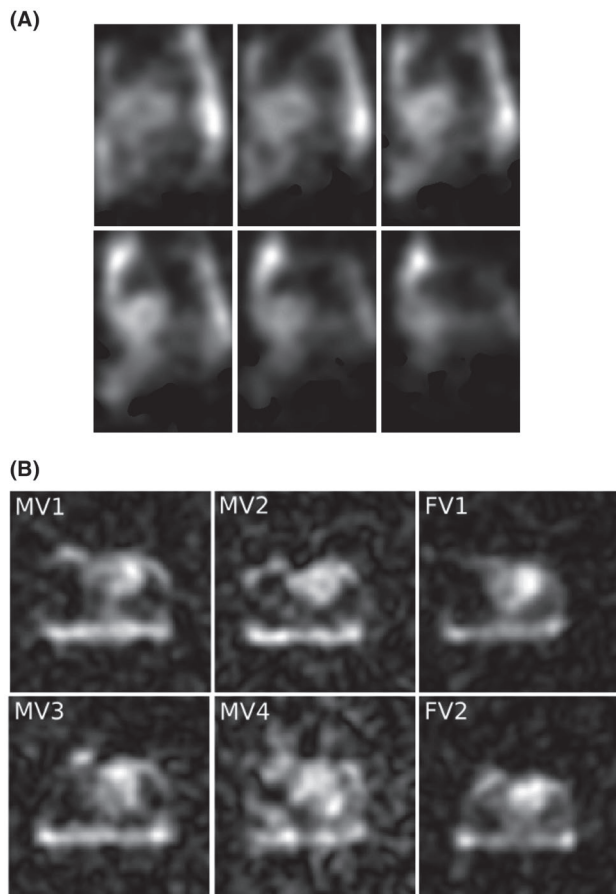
(A) Six slices of in vivo ^{39}K images of the same volunteer as in Figure 6 obtained using DA-3DPR imaging; filtered with Hamming filter and four-time zero filling and demonstrated in short axis (SAX) view. The images were acquired with nominal isotropic resolution = $14.5 \times 14.5 \times 14.5 \text{ mm}^3$ within 30 min by using following parameters: TR/TE = 30/0.7 ms, number of projections = 20,000, readout duration = 5 ms. (B) In vivo ^{39}K MR images, shown in axial view, obtained from 6 healthy volunteers: 4 male (MV1, MV2, MV3, MV4) and 2 female (FV1, FV2) using the same imaging technique as in Figure 6, but different MR system (Terra, Siemens Healthineers, Erlangen, Germany)
